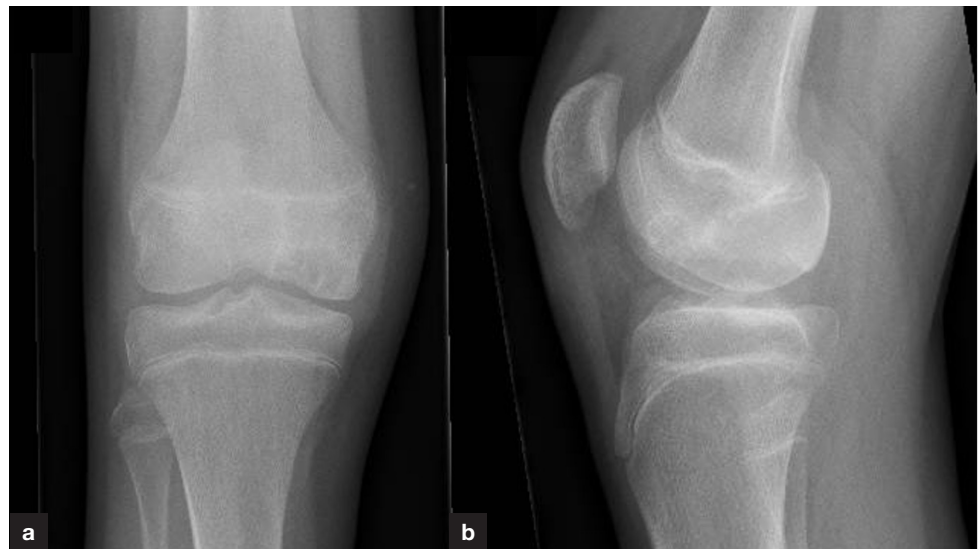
An (a) anterior-posterior and (b) lateral X-ray of the knee demonstrating a medial femoral condyle osteochondral defect.
